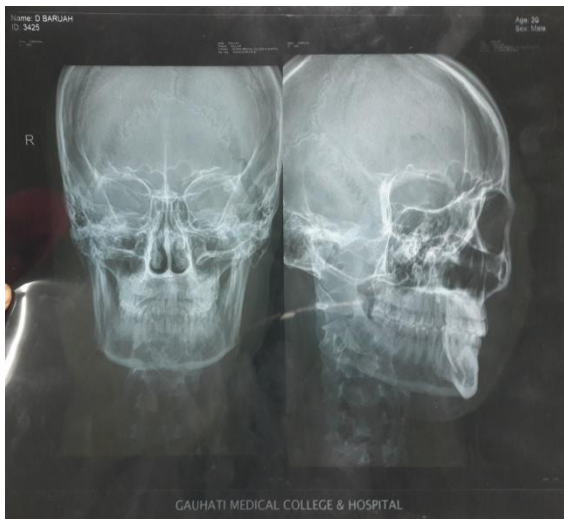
X-Ray orbit AP and Lateral view showing orbital emphysema
